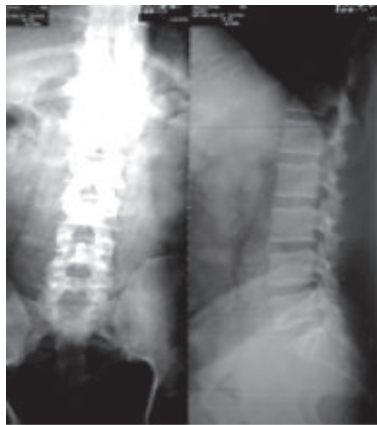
X-ray lumbosacral spine A/P & Lateral view.
